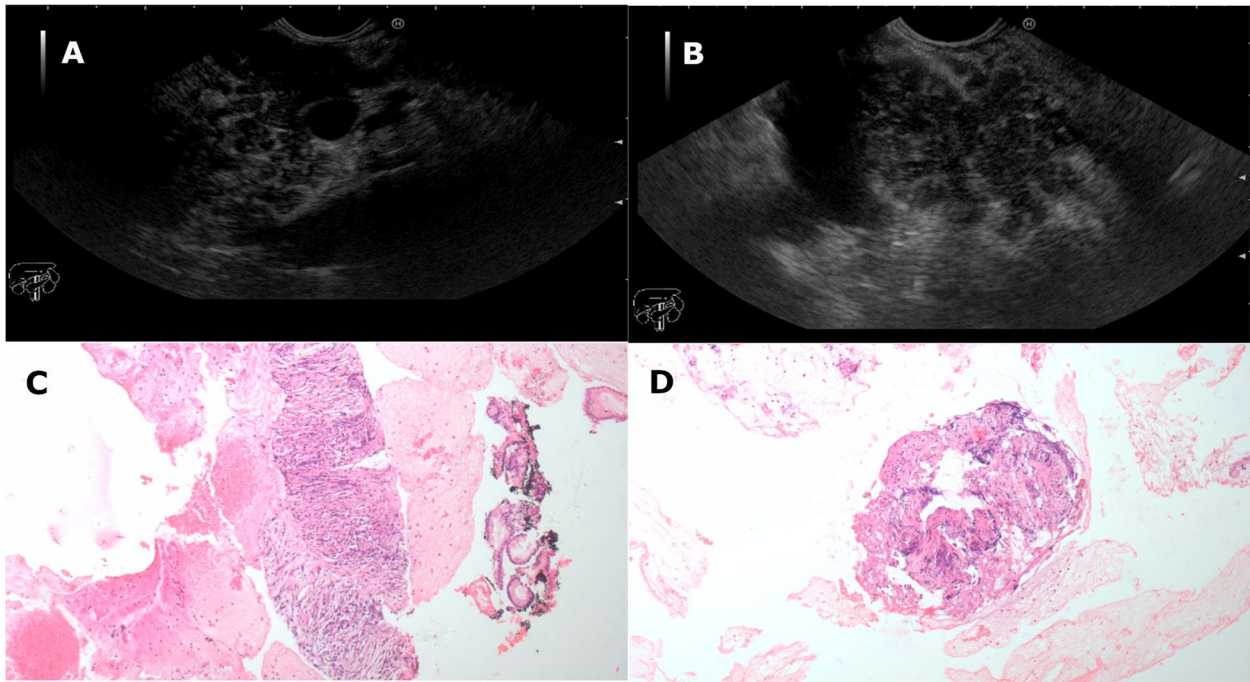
Endoscopic ultrasound images showing a pancreatic head with a picture of chronic pancreatitis “hyperechoic strands and lobulations” (A, B). Cytopathological examination of EUS-guided fine needle aspiration revealed a diagnosis of autoimmune pancreatitis (C, D) with dense fibrosis with scattered mixed chronic inflammatory cells. The inflammatory cells are formed mainly of lymphocytes with scattered plasma cells and some eosinophils
